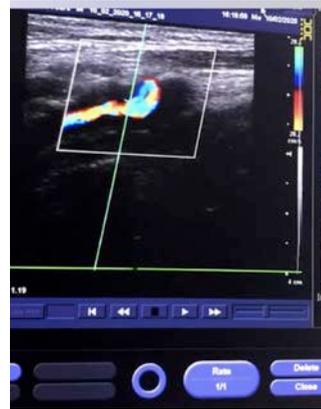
Doppler ultrasonography of carotid artery.
